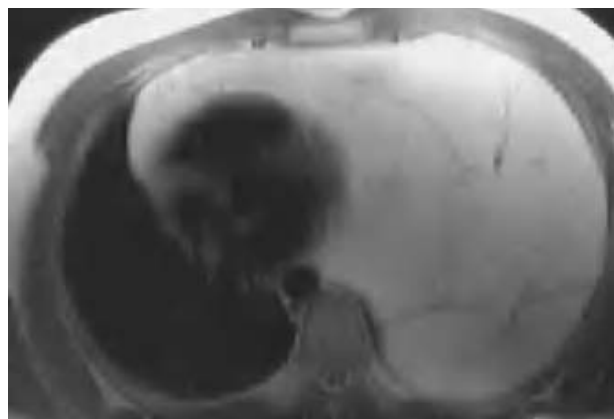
Chest magnetic resonance image showing a large mass in left side of the chest. The mass is isointense to fat and occupies the pleural cavity and the anterior mediastinum, causing complete collapse of the lung.
